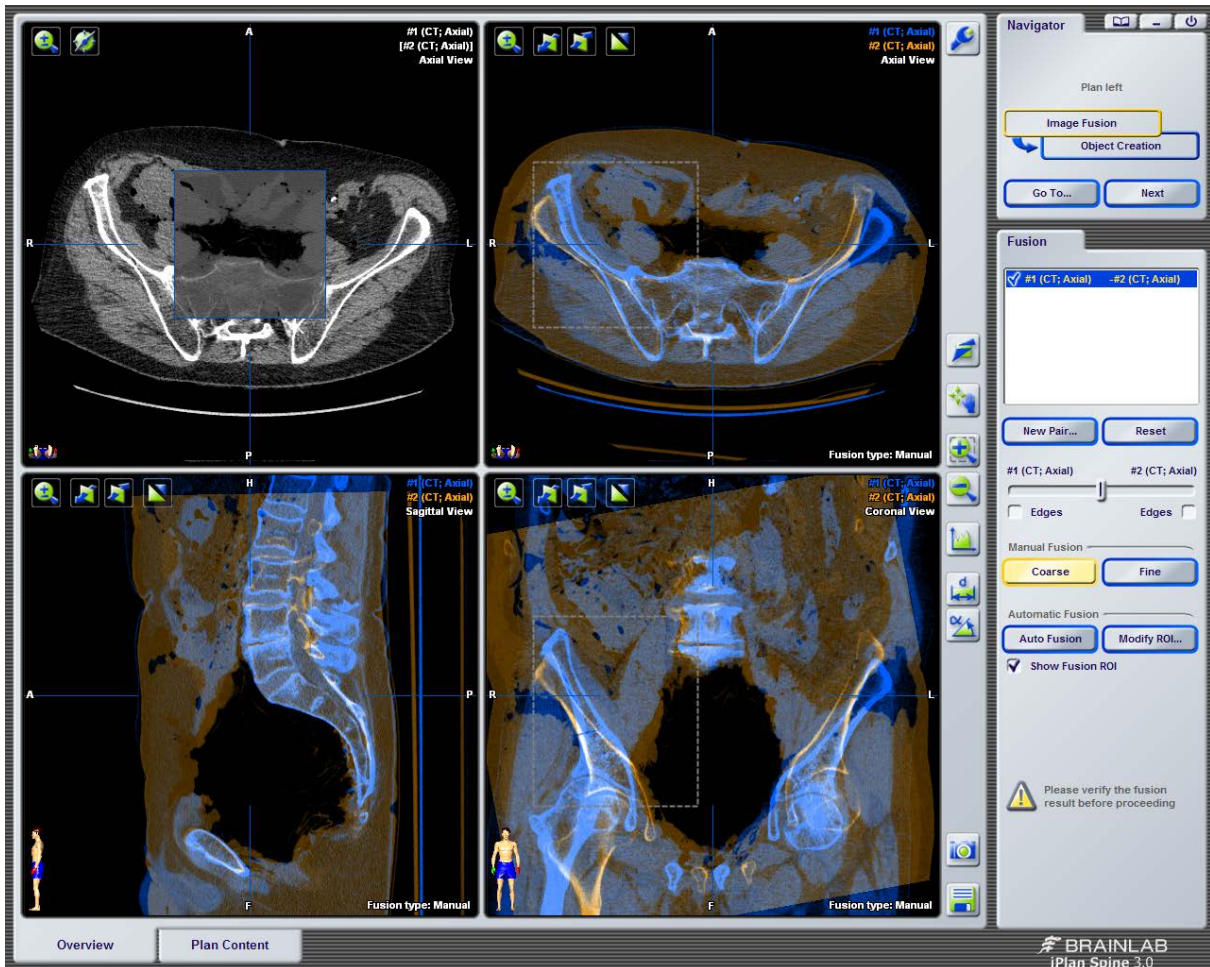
Preoperative and postoperative CT scans before image fusion
